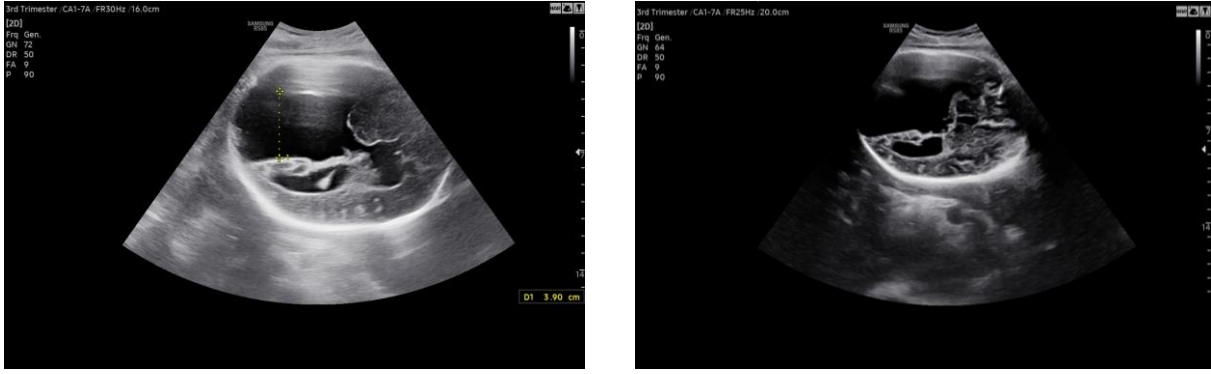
In (a) and (b) in antenatal sonography, the image of the left lateral ventricle continuous with the subarachnoid space is look like schizencephaly and CSP is not observed.
